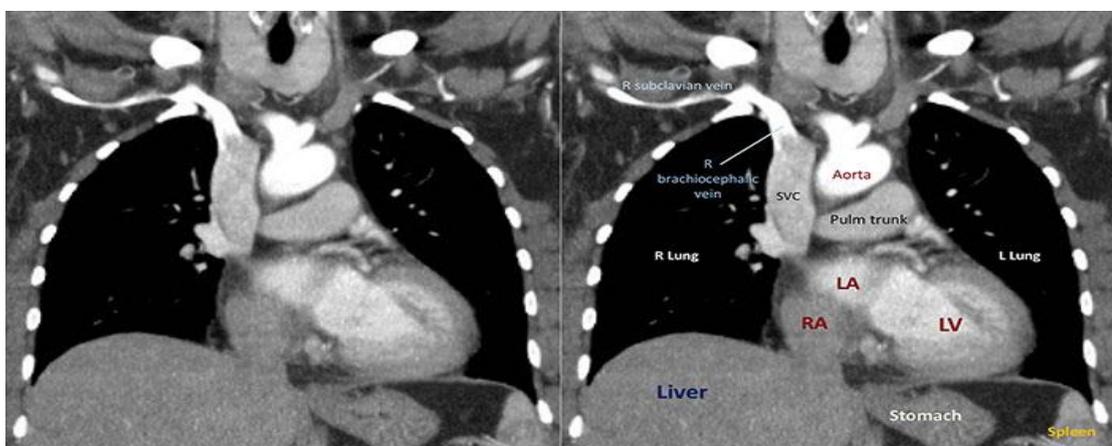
Coronal reconstruction of a chest CT scan in arterial phase showing normal anatomy of the labeled structures (Stephanie, 2011).
